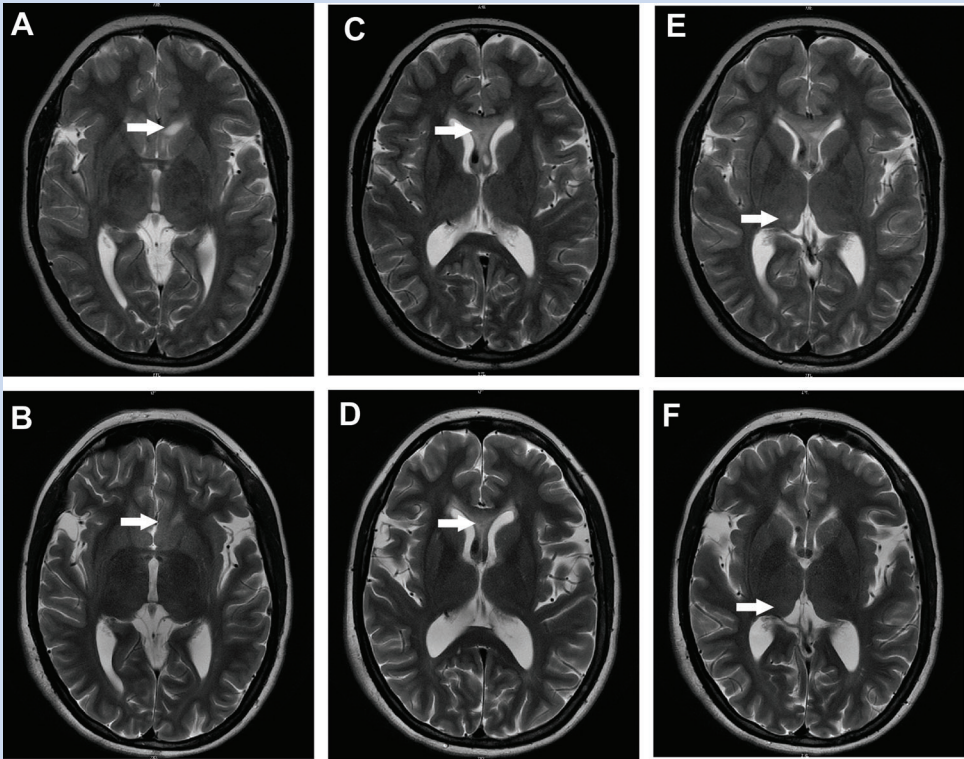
A series of T2 weighted MRI images from the same individual from 1999 (A, C, E), and 2009 (B, D, F). A: Discrete T2H in the left frontal region (indicated by white arrow), which had completely resolved by 2009 (B). C: Diffuse triangle-shaped region of hyperintensity in the genu of the corpus callosum (white arrow), which was much less extensive and less prominent in the 2009 image (D). E: Diffuse lesion in the right thalamus (white arrow), which had resolved by 2009 (F).
